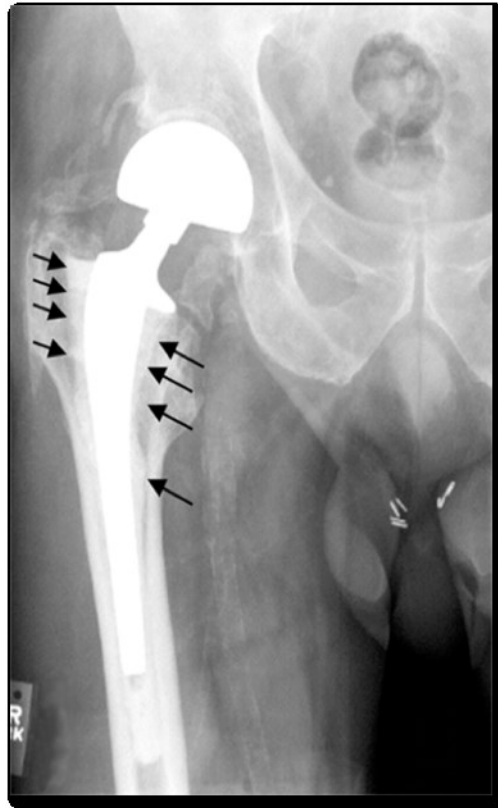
X-ray image depicting osteolysis (arrows) around a hip implant [50]. Reproduced with permission from BioMed Central Ltd.
